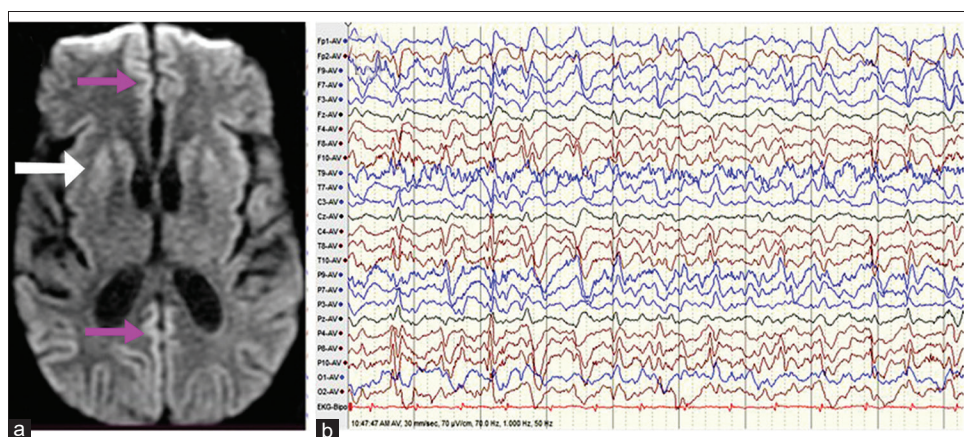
Axial DWI section of MRI brain (a) depicting cortical ribboning along bilateral parieto-occipital and frontal lobe (white arrow), bilateral insular cortex, and diffusion restriction in bilateral corpus striatum (pink arrow) and (b) electroencephalogram showing characteristic periodic sharp wave discharges (Rademecker complex)
